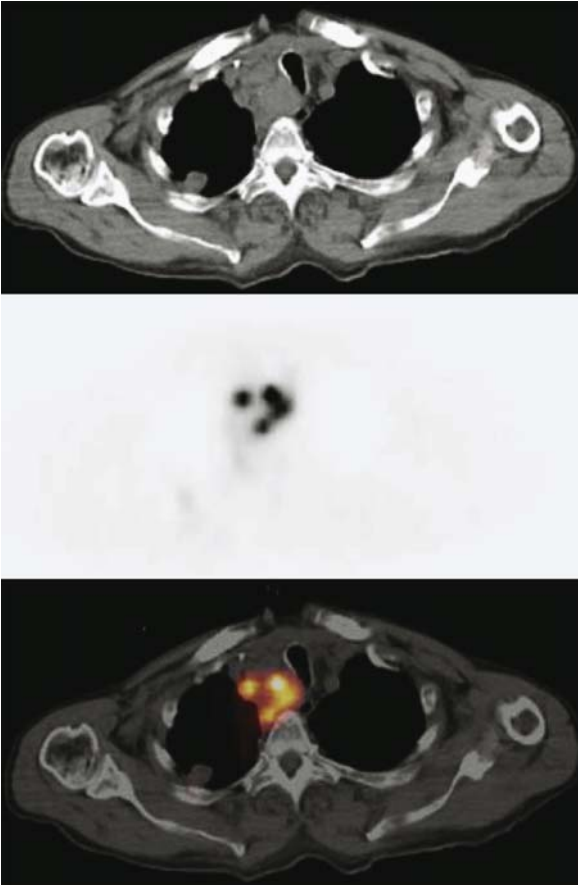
¹²⁴I PET (A), CT (B), and PET/CT (C) images acquired 24 h after oral administration of 50 MBq show pathological tracer uptake mediastinally representing four iodine-avid mediastinal metastases. Additional non-iodine-avid metastases were found in the mediastinum and lung
